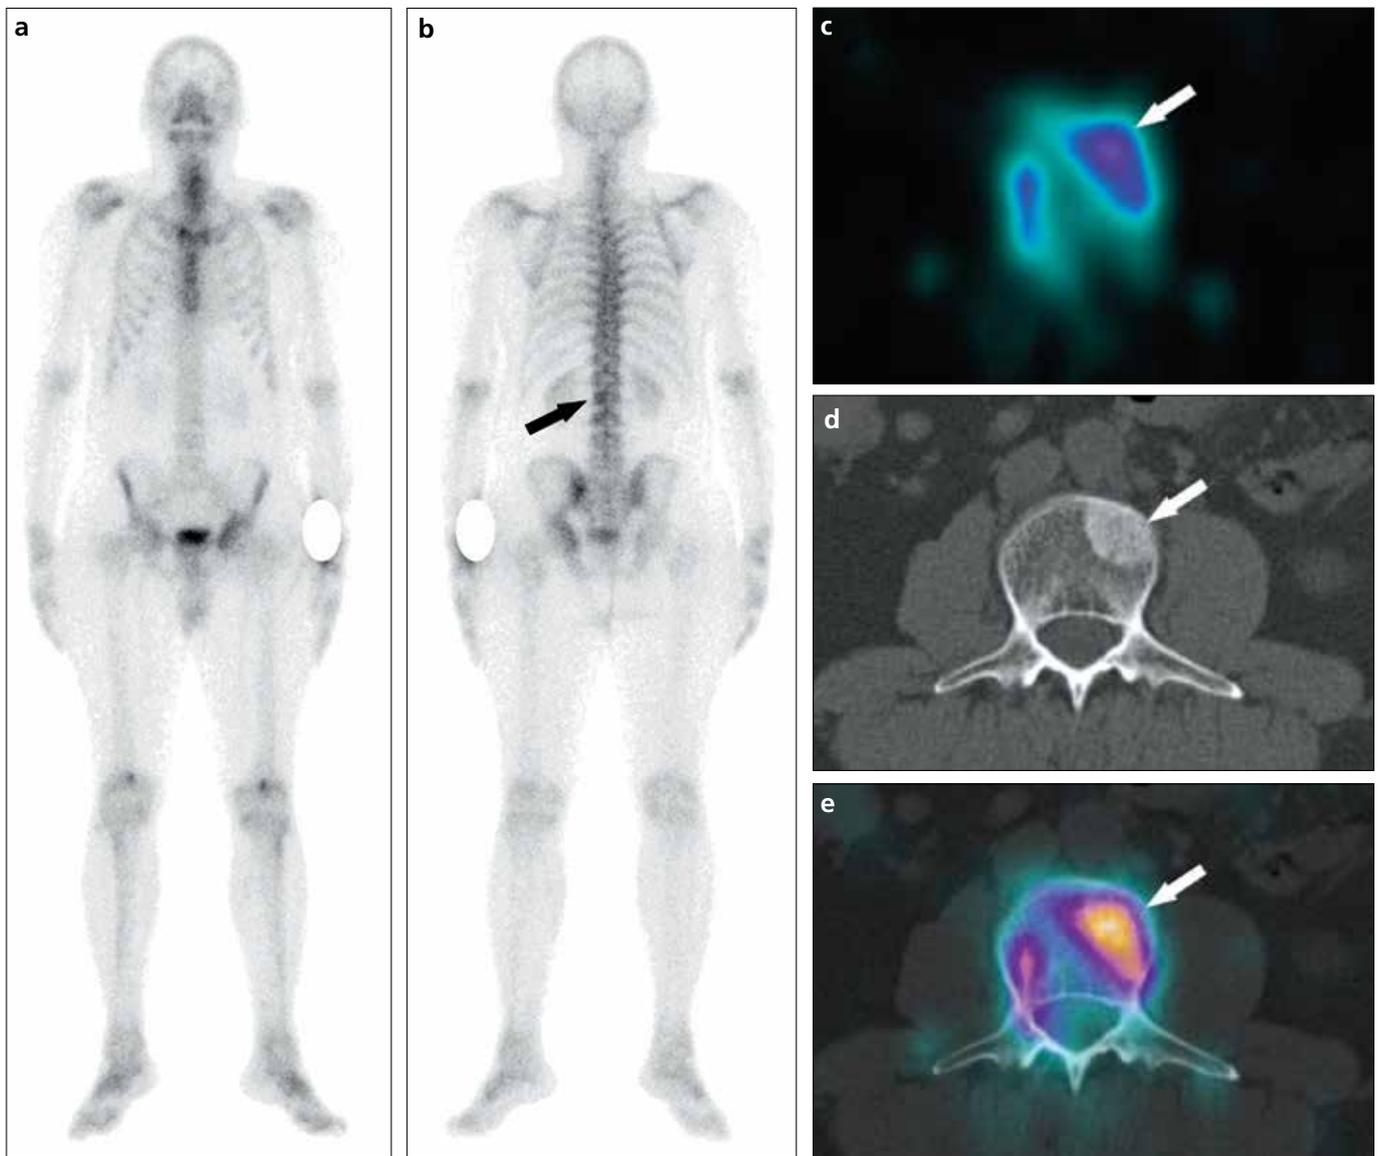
a–e. A 53-year-old male patient, a follow-up case of carcinoma of the prostate, presented with rising levels of the prostate specific antigen. Bone scintigraphy was performed to evaluate bone metastasis. Planar bone scintigraphy images (a, b) show faint focal uptake in the L2 vertebra (*arrow*; score 3). Axial SPECT (c) image shows uptake in the body of the L2 vertebra (*arrow*; score 2). Axial CT (d) and SPECT-CT (e) images show a sclerotic lesion in the body of the L2 vertebra with increased tracer uptake (*arrow*; score 1). On these images, SPECT, CT, and SPECT-CT characterized the planar scintigraphy indeterminate lesion as metastatic.
